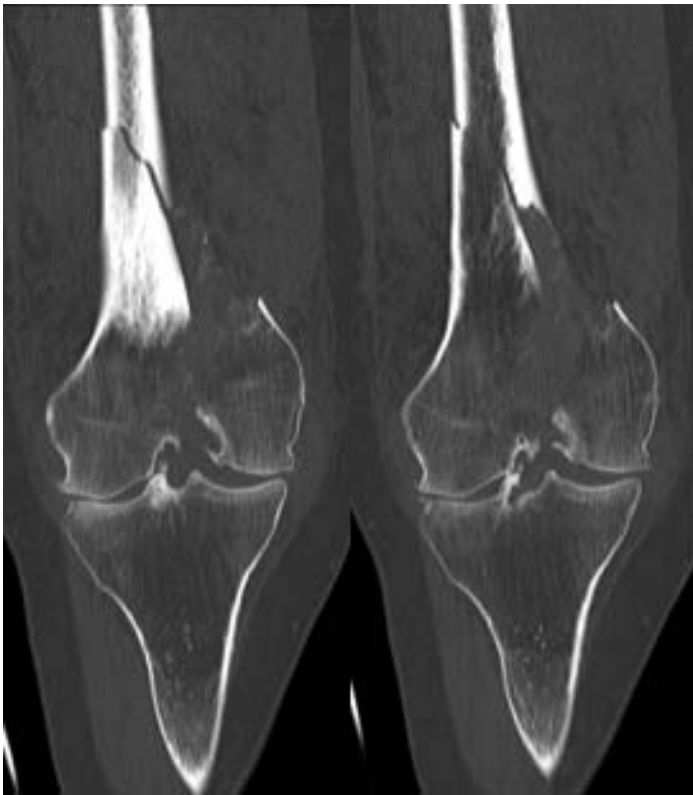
Case 1: CT scan of distal supracondylar femoral fracture showing comminution, intra-articular extension, and medial femoral condyle displacement. Reconstruction in this case would have required open knee arthrotomy in addition to lateral plating in order to address both the articular and distal femoral shaft components of the fracture.
